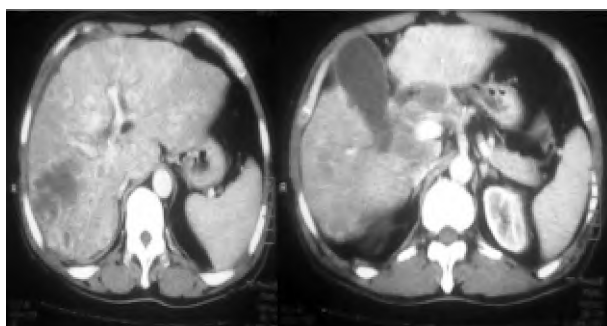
Multislice CT axial image showed hypodense soft tissue mass at the head of pancreas extending into the uncinate process as well as neck of pancreas associated with multiple bilobar variable sized and density hepatic focal lesions some showed "target sign" metastatic deposits.
